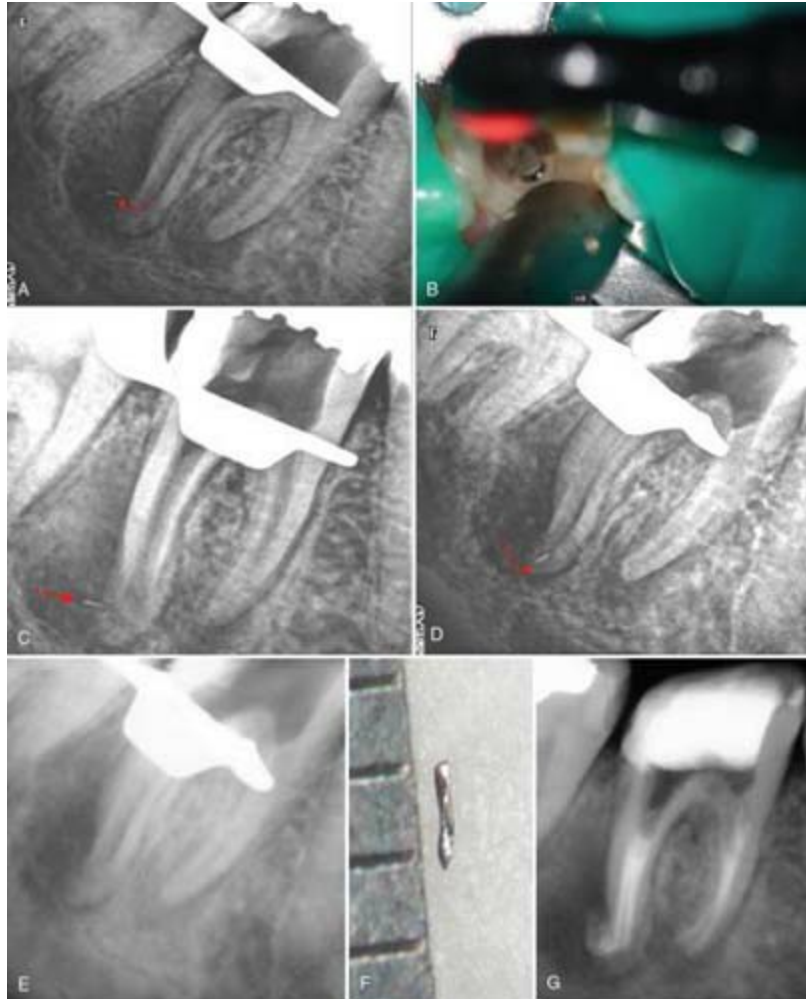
A, Separated file pushed beyond the radicular foramen. B, PiezoFlow activated using saline to create cavitation and acoustic stream. C, Separated file approaching the radicular foramen with the PiezoFlow. D, Separated file brought back into the canal. E, Separated file retrieval confirmed on the radiograph. F, Retrieved separated file on a ruler. G, Root canals obturated with mineral trioxide aggregate (MTA).
